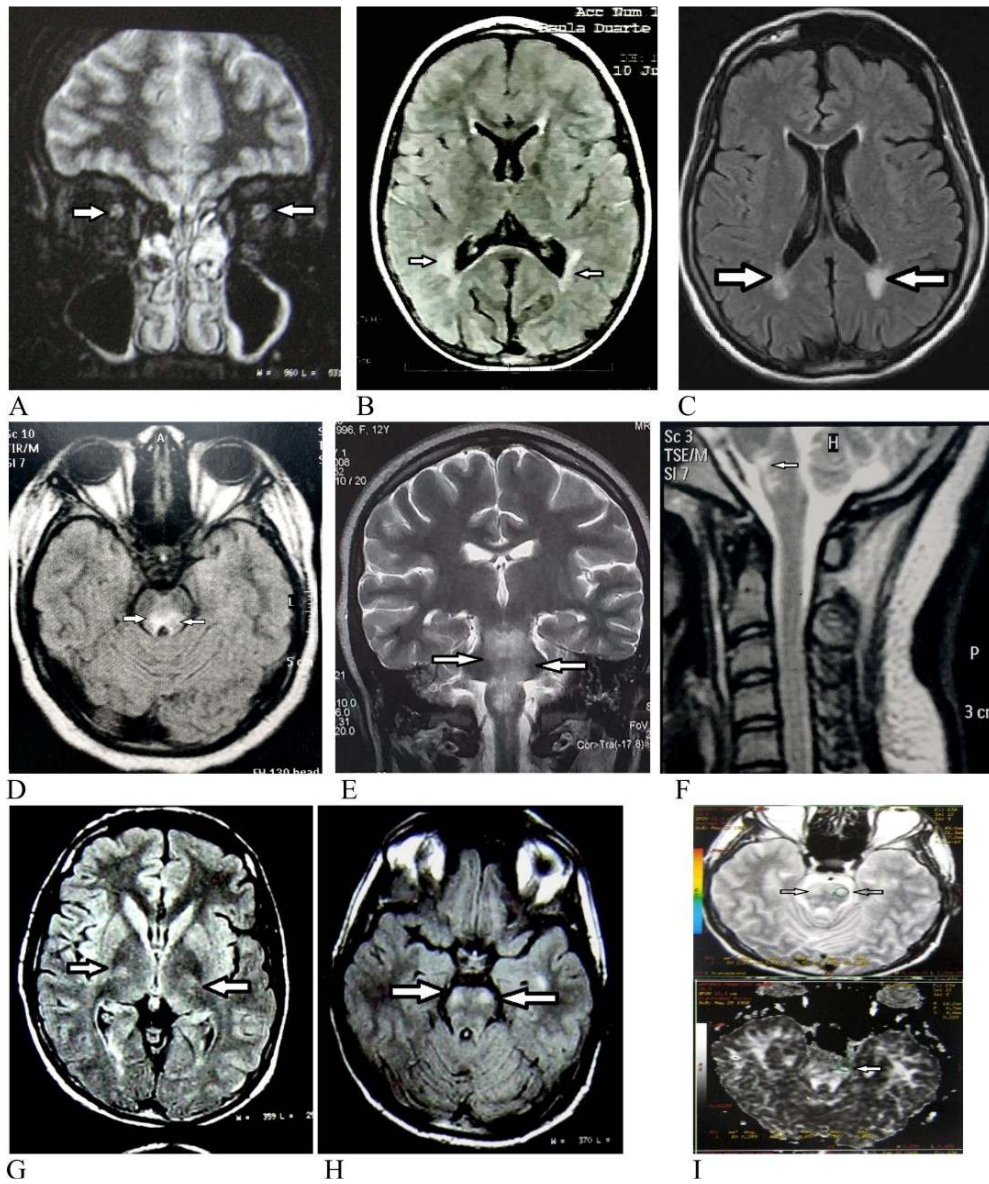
A (Case 10) - T2 sequence, coronal plane: bilateral atrophy of the optic nerves. B (Case 5), C (Case 7), D (Case 6) and G (Case 9) - Sequences FLAIR, axial planes: In B, C and G: periventricular lesions with hyperintensity in subsequent extensions of the lateral ventricles (arrows). D - periventricular hyperintense lesion with the fourth ventricle extending to the midbrain (arrow). E (Case 6) - T2 sequence, coronal plane: coalescing lesions with hyperintensity in brainstem. F (Case 6) - T2 sequence, coronal plane: hyperintense lesion in the area postrema. G (Case 9) - Sequence FLAIR, axial plane: Bilateral lesions with hyperintensity in the posterior limb of the internal capsule in the path of the corticospinal tract. H (Case 9): T2 sequence axial: bilateral lesions in the midbrain, following the path of the corticospinal tract. I (Case 9): diffusion tensor sequences, axial planes G and H, indicating a reduction of anisotropy in corresponding locations to the corticospinal tract
